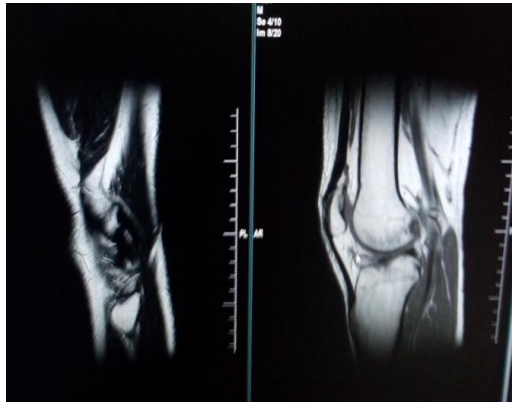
MRI lateral view of knee joint
